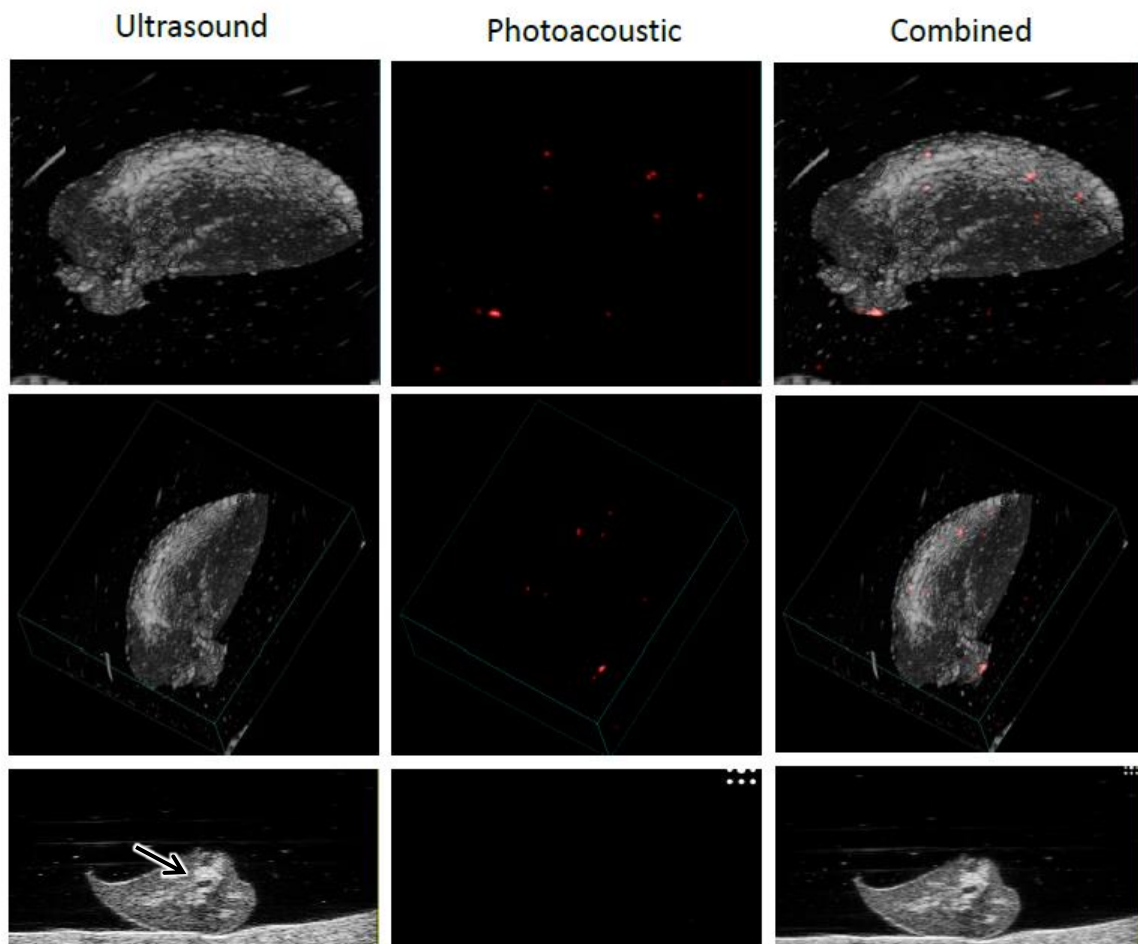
Ultrasound-guided photoacoustic imaging of an optimized acellular scaffold. Imaging reveals absence of photoacoustic signal at 750nm. A void in the scaffold representing the bronchus can be seen in cross-sections of the ultrasound images (arrow).
